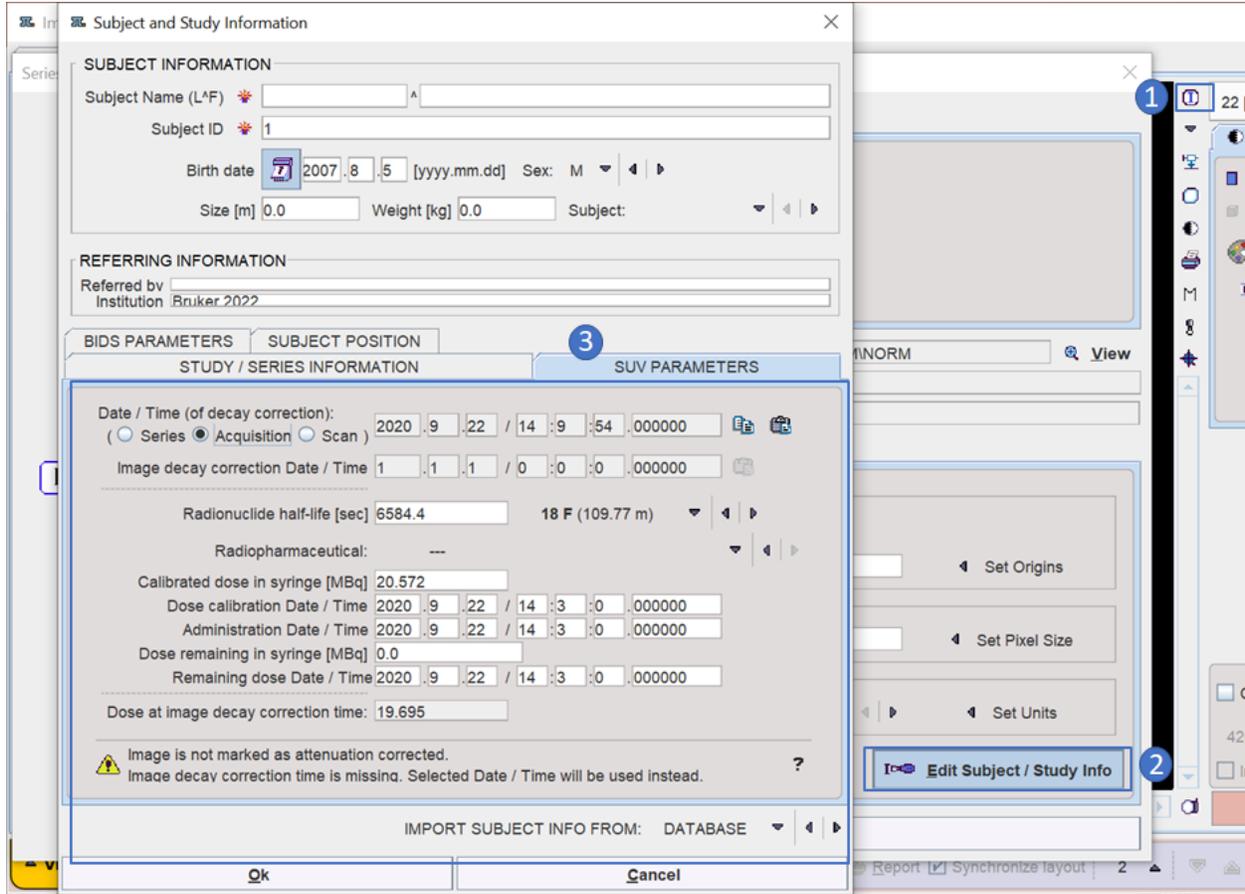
PMOD 4.3 Isotope/Compound/Dose Information. To view the PET Isotope/Compound/Dose header information, select 1) Information, 2) Edit Subject/Study Info and SUV Parameters.
